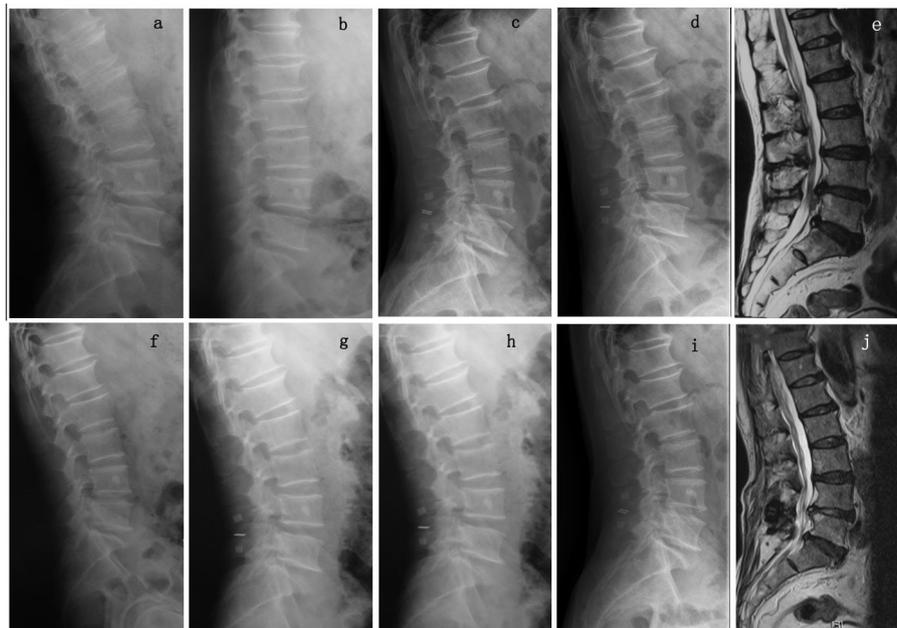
The Wallis interspinous device (Zimmer, Warsaw, IN, USA) was inserted into the L4–5 level of this patient with multi-segmental lumbar degenerative disease. a, b) preoperative flexion and extension radiograph; c, d) flexion and extension radiograph at last follow-up; e) preoperative lateral T2-weighted MRI showing L4–5 disc herniation; f) preoperative lateral radiograph; g) lateral radiograph 3 months after surgery; h) lateral radiograph 1 year after surgery; i) lateral radiograph 5 years after surgery; j) lateral T2-weighted MRI 5 years after surgery.
